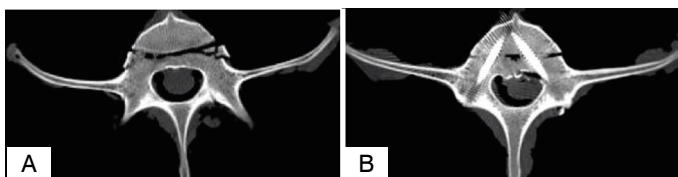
(A) Computed tomography of lumbar segment L3 vertebra after coronal split fracture (B) Computed tomography of lumbar vertebra L3 after osteosynthesis with cannulated screw, pedicular fixation.
